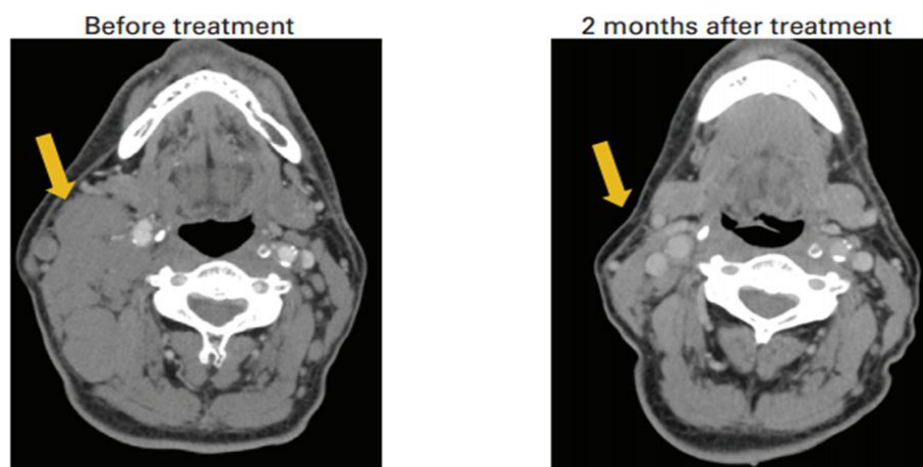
PET/CT image show CR of lymphoma in patient
